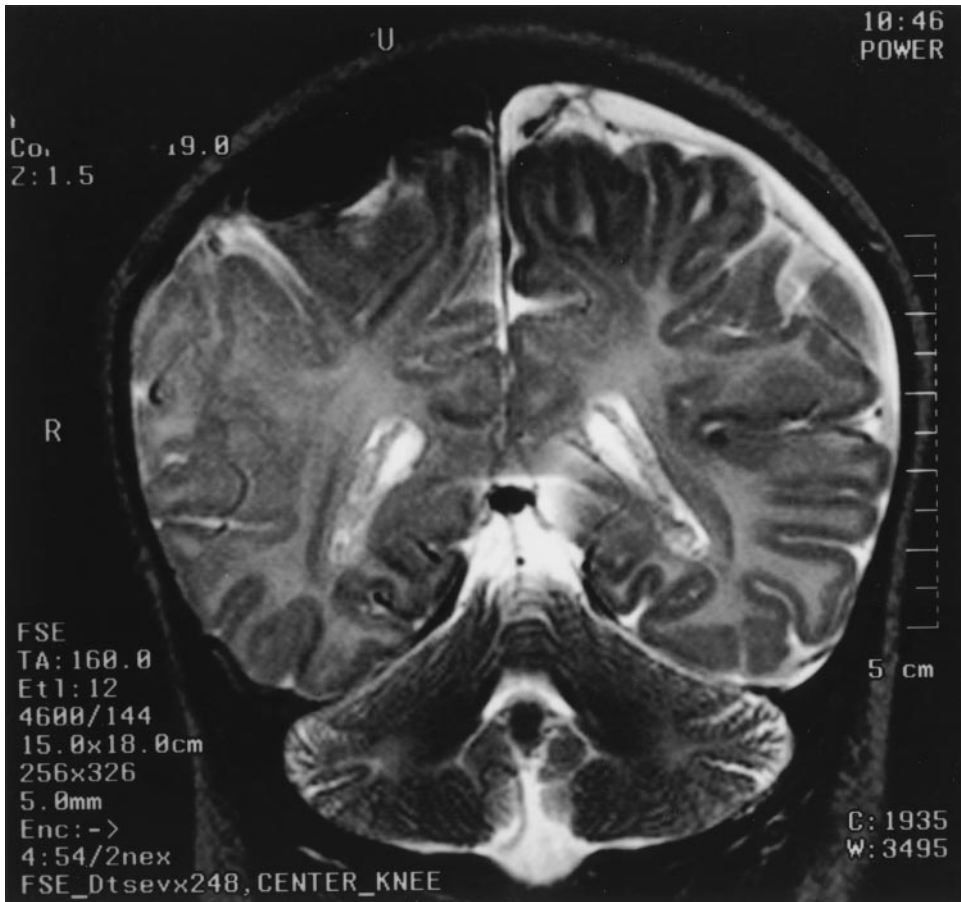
In patient 10, MRI showed several subdural hematomas of different ages in both frontal areas.
